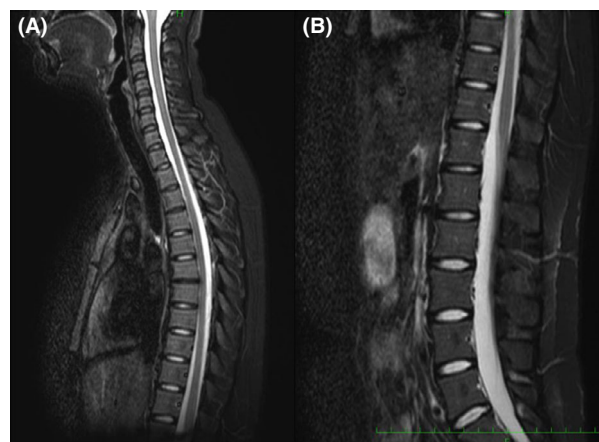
Follow-up magnetic resonance imaging (MRI) of a 19-year-old woman diagnosed with surfer's myelopathy. A, Cervical and thoracic spine MRI on day 6. B, Lumbar spine MRI on day 9.
